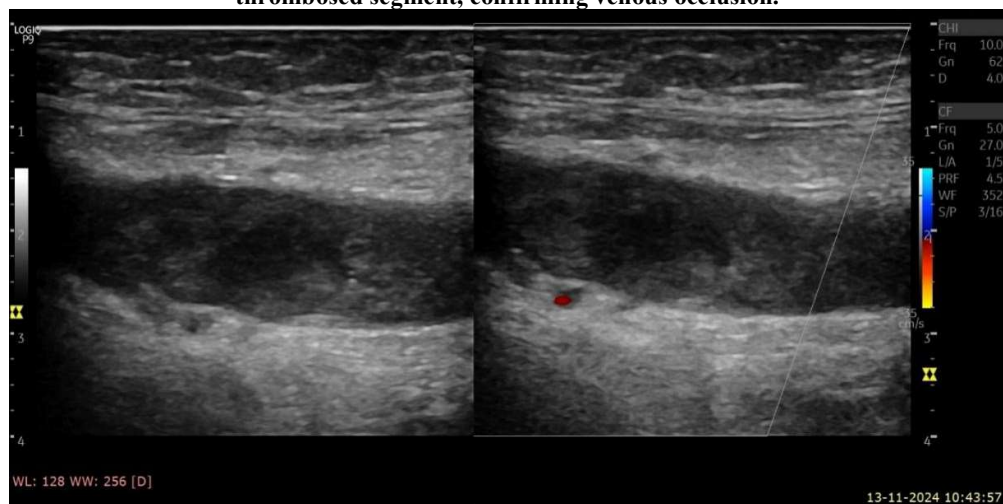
Longitudinal grayscale ultrasound image of the left common femoral vein demonstrating echogenic intraluminal thrombus.
